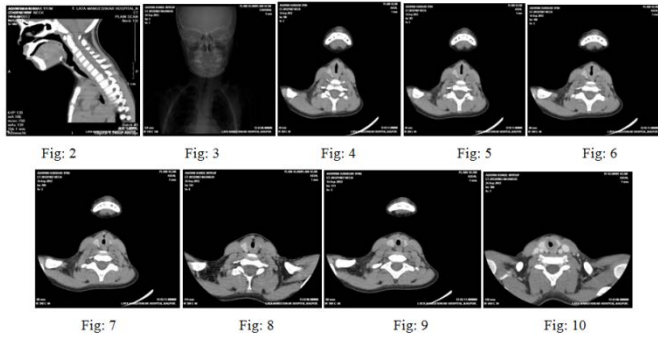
CT scan examination of airway
